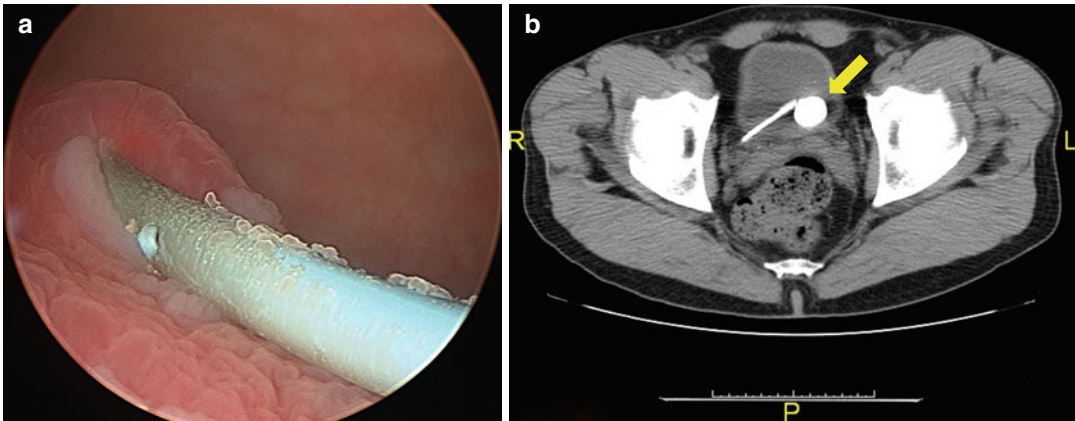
(a) Cystoscopic view from the bladder demonstrating calcifications along the outside of a stent protruding through the ureteral opening (orifice); (b) Axial CT
